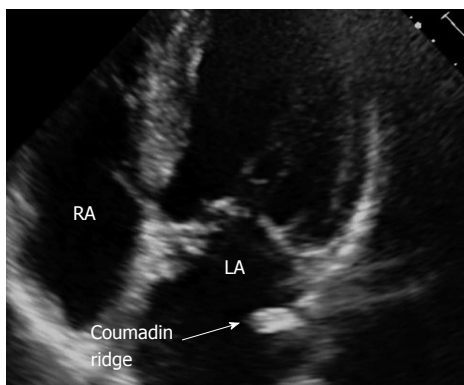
Apical transthoracic echocardiography view of coumadin ridge in the left atrium. RA: Right atrium; LA: Left atrium.
